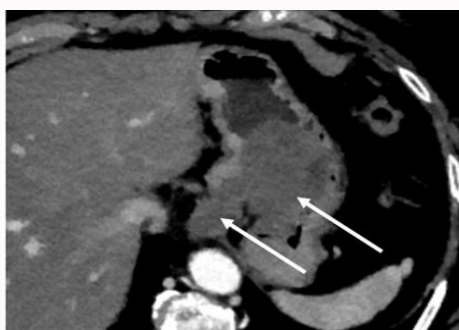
Contrast enhanced CT scan of the abdomen showed a huge posterior gastric GIST measuring 9 cm x 10 cm with an intraluminal growth.
